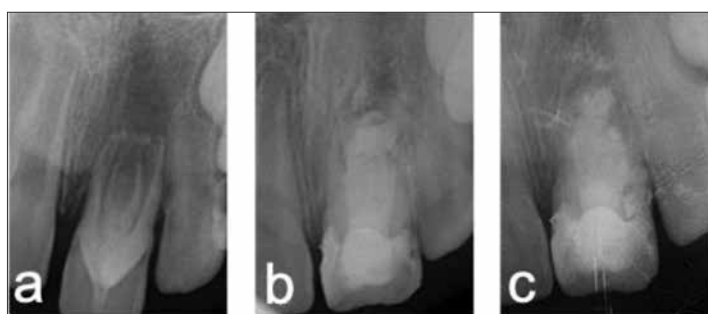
Radiographic appearance of case 5; a – preoperative; b – postoperative; c – postoperative 24-month follow-up
